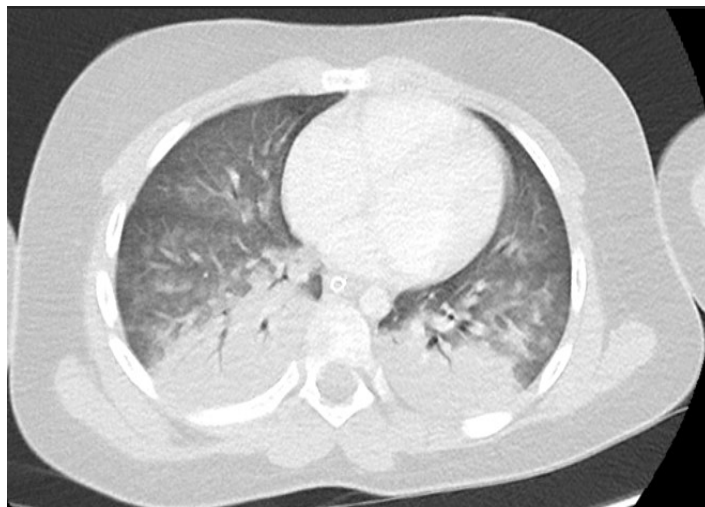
Lung window images of non-enhanced thorax CT. The lower lobes of both lungs demonstrate multiple alveolar infiltrates that coalesce posteriorly, forming areas of consolidation with positive air bronchograms.
